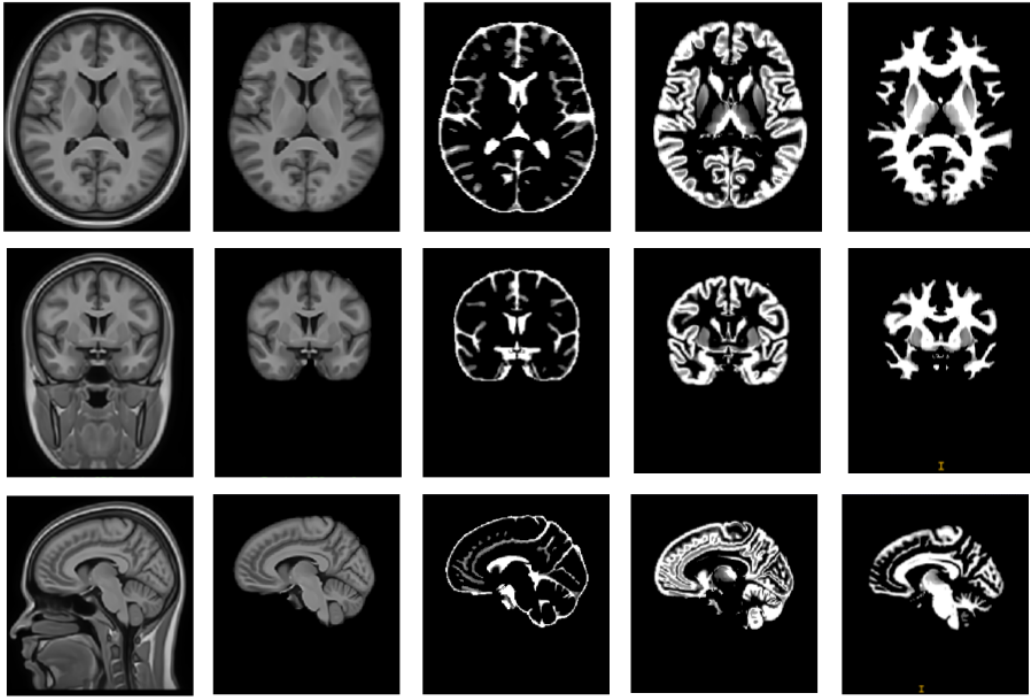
Indian brain template (i.e., IBA100) of the young population together with its tissue probability maps. Top to bottom: Axial, Coronal and Sagittal slices. Left to right: MRI, skull stripped brain, Cerebrospinal Fluid (CSF) probability map, Grey Matter (GM) probability map and White Matter (WM) probability map
